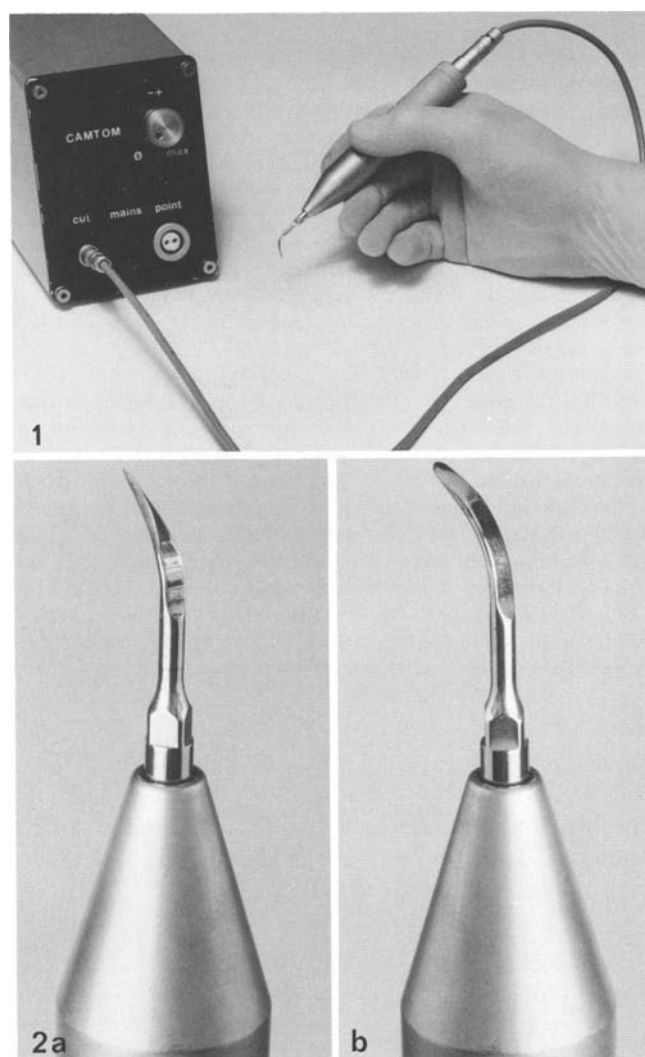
Ultrasonic scalpel
